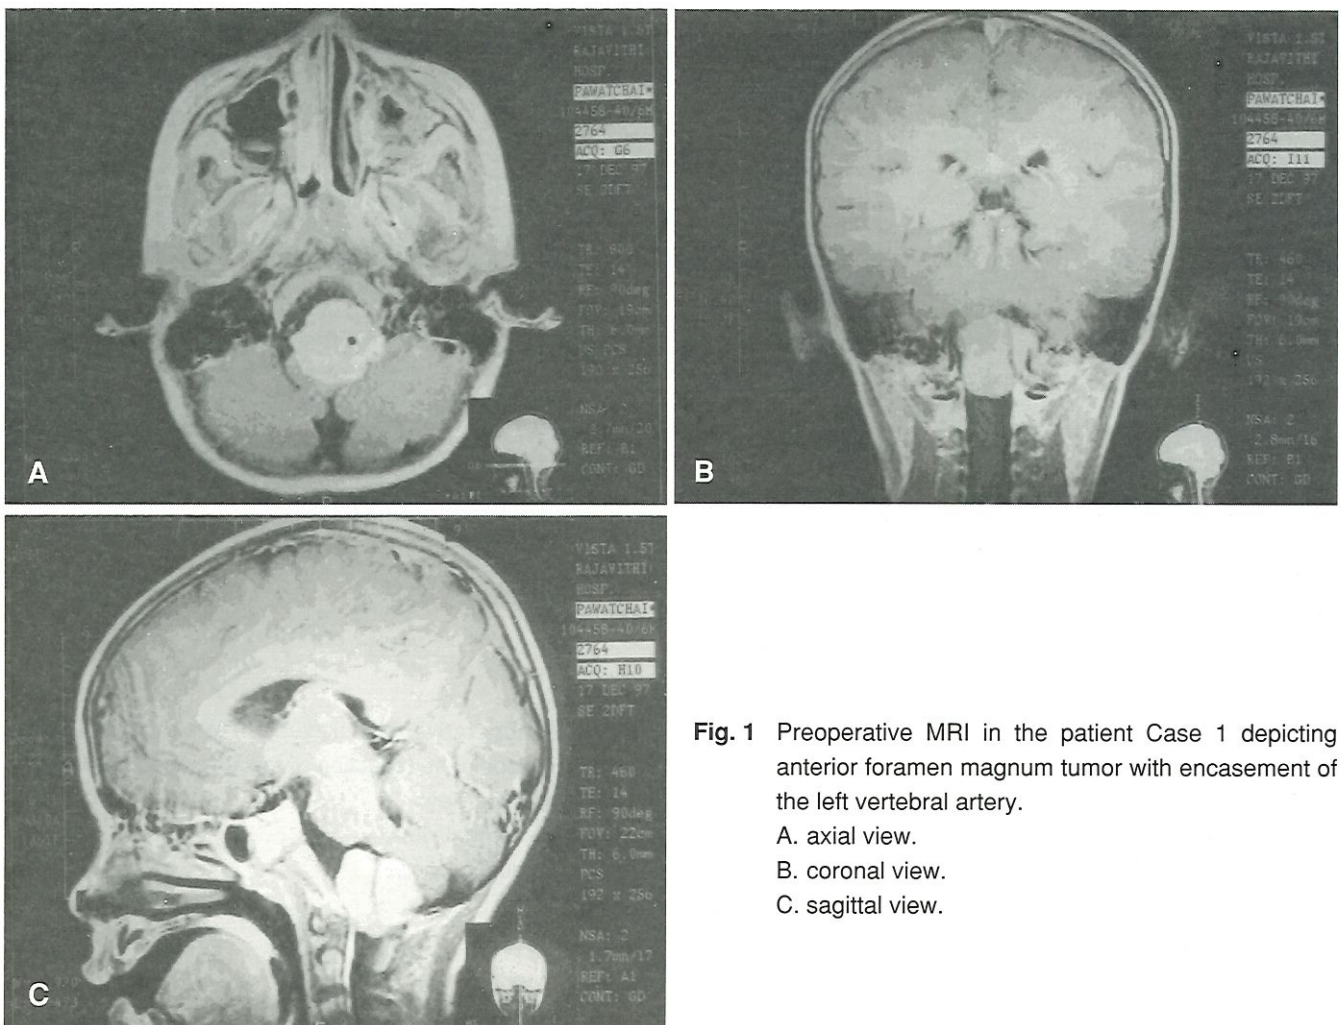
Preoperative MRI in the patient Case 1 depicting anterior foramen magnum tumor with encasement of the left vertebral artery.
